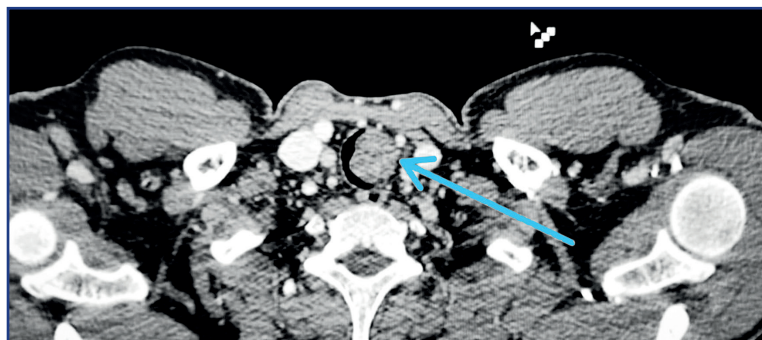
CT image of the tracheal tumor
